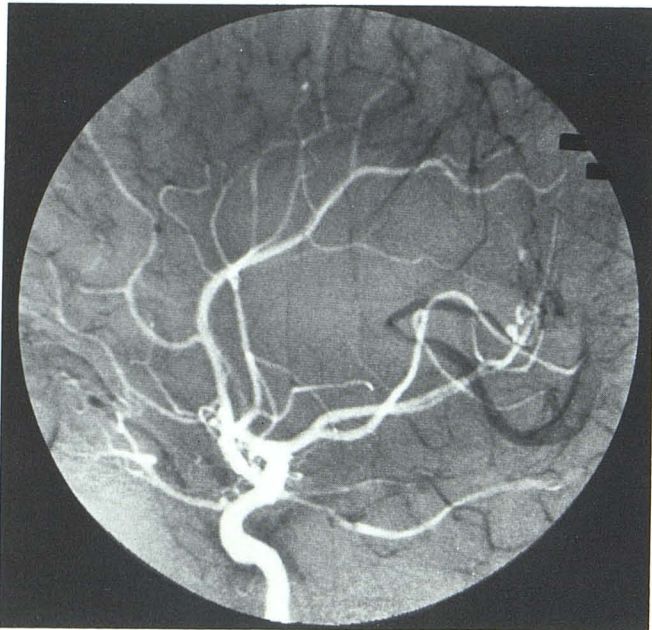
Arteriovenous malformation in 15-year-old girl with intracerebral hemorrhage on CT; emergency arteriography prior to removal of hematoma. Lateral view of right internal carotid injection (volume, 5 ml; rate, 3 ml/sec). Digital subtraction of frame in capillary phase from mask (frame from early arterial phase) shows abnormal venous drainage (*black*) of low-flow arteriovenous malformation into internal cerebral vein and vein of Galen. Arterial feeding vessel, a posterior sylvian branch of middle cerebral artery (*white*), supplies small tangle of vessels representing malformation.
